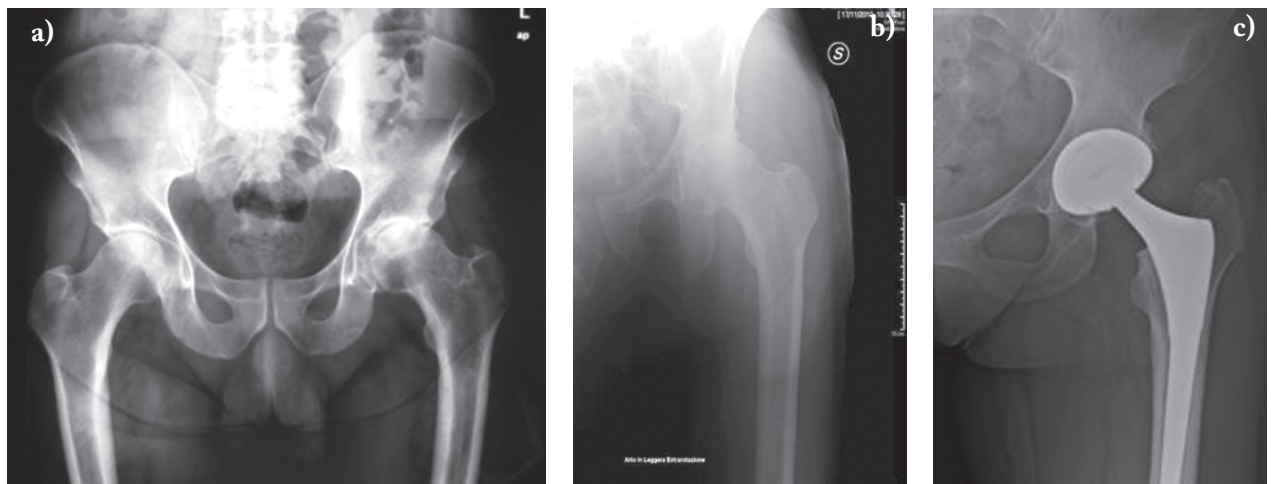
a, b, c. Post operative radiographies, after 12 months (2a), after 3 years (2b)
